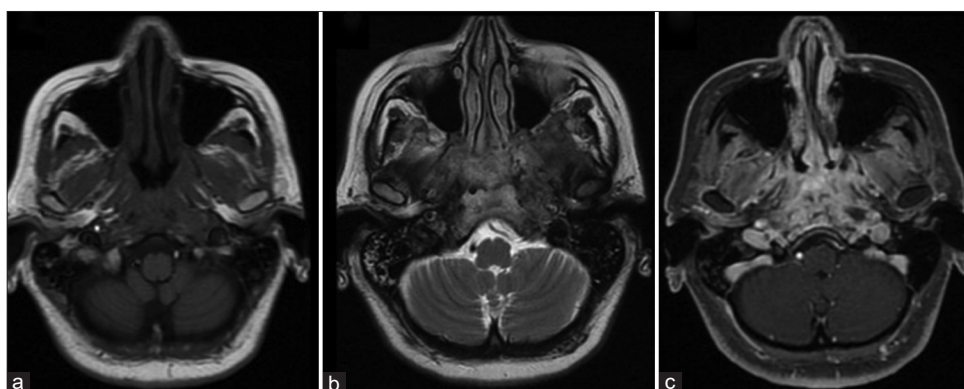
Axial magnetic resonance imaging demonstrating a hypointense lesion with sphenoid body and clival bone involvement (a) infiltrating nasopharyngeal submucous tissue (b) with a hypointense appearance in T1 and T2 sequences. Gadolinium enhancement in T1 of sphenoid and clival bone tissue.
